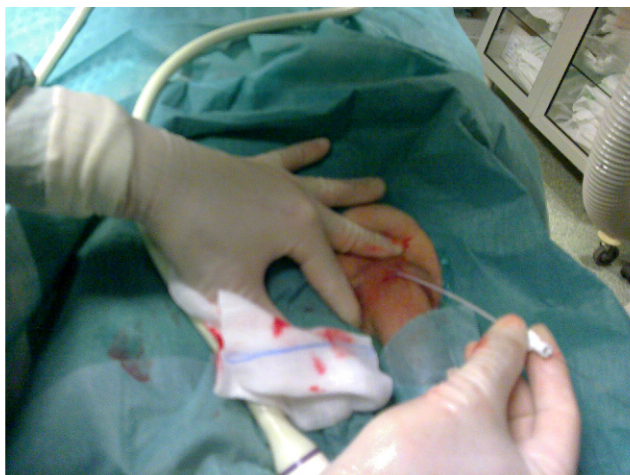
Ultrasound-guided puncture of DDV with a linear probe. (Available in color online at www.jvir.org.)
